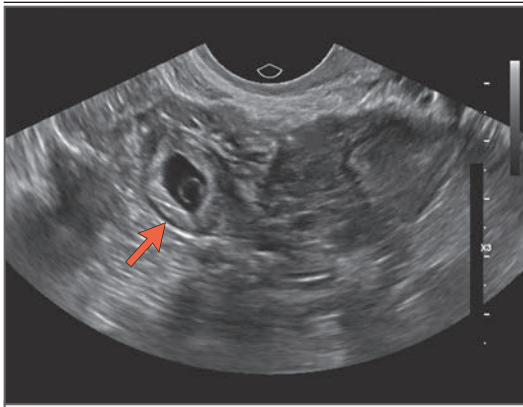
Transvaginal Ultrasonogram of Definitive Tubal Ectopic Pregnancy.
